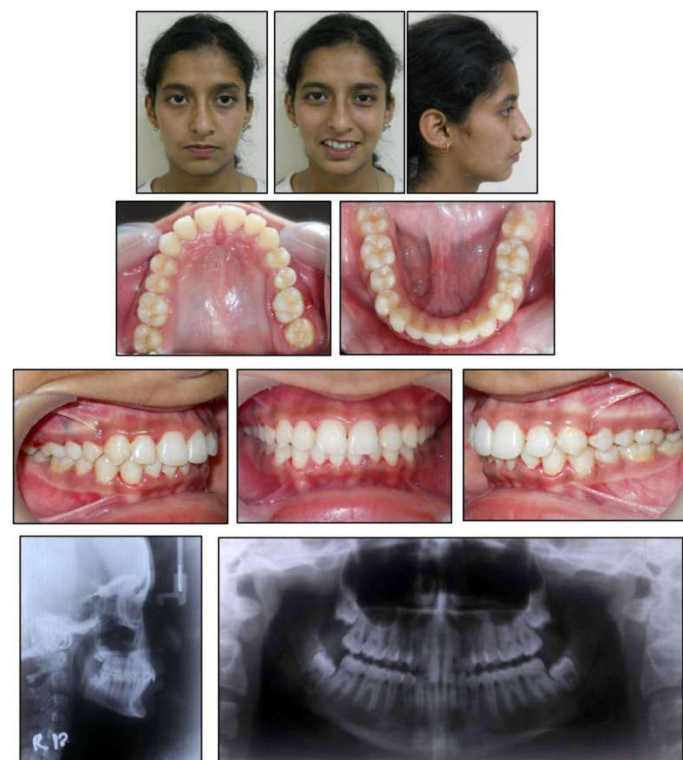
Post treatment intraoral and extraoral photographs and radiographs
